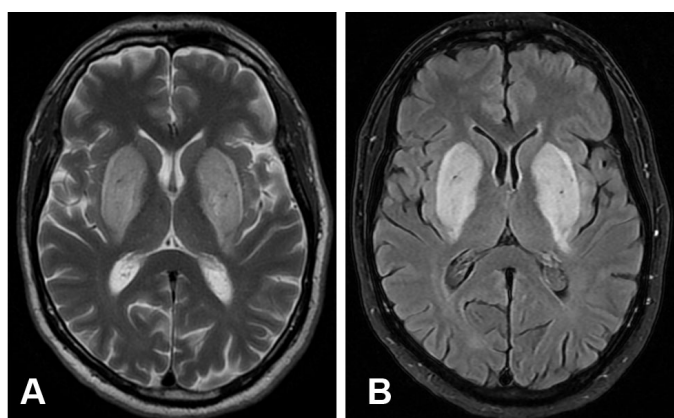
Brain MRI, axial sections. (A) T2-weighted sequence and (B) FLAIR showing the basal ganglia with hyperintense signal, symmetrical and bilateral, surrounded by a hyperintense rim delineating the lentiform nucleus, representing the lentiform fork sign.
